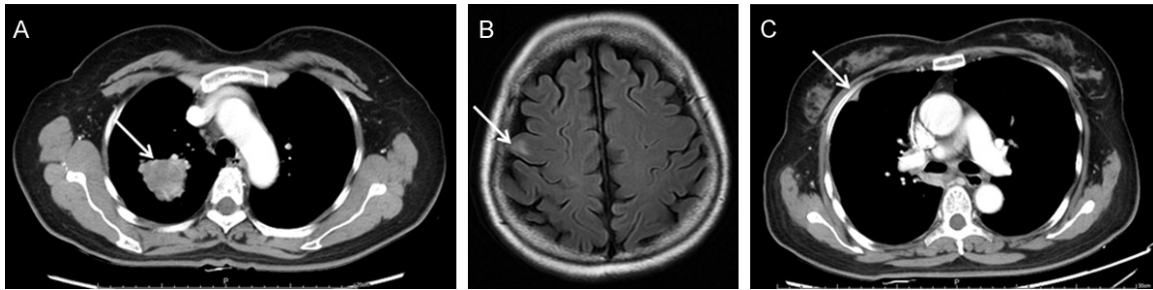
CT scan (A) CT scan showed a space occupying focus (arrow) in the superior lobe of the right lung. (B) Cranial MRI enrichment showed abnormal strengthening signals (arrow) in the sub-cortex of the right frontal lobe. (C) PET-CT showed high metabolic changes in the right-sided sub-pleural lymph nodes.
